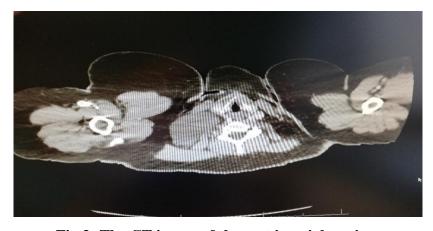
The CT image of the cyst in axial section.
